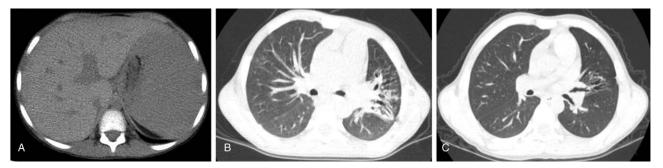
Imaging features of abdomen and lung in a patient. (A) Abdominal contrast-enhanced CT revealed hepatosplenomegaly. (B) Lung CT scan showed partial consolidation of left upper lung with bronchiectasis and left upper bronchial stenosis (prior treatment). (C) Lung CT scan showed partial consolidation of left upper lung with bronchiectasis and left upper bronchial stenosis (post-treatment).
